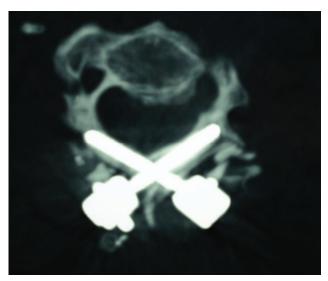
Postoperative axial computed tomography image showing a proper position of the C2 translaminar screws.
